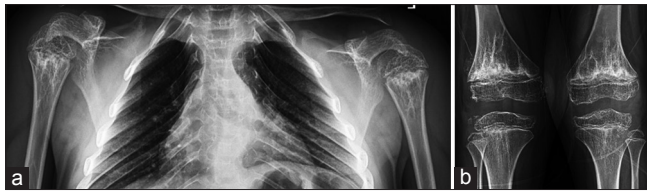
(a and b) Radiographs of a child showing irregular frayed and splayed metaphysis with serrated margins predominantly affecting humerus and femurs
